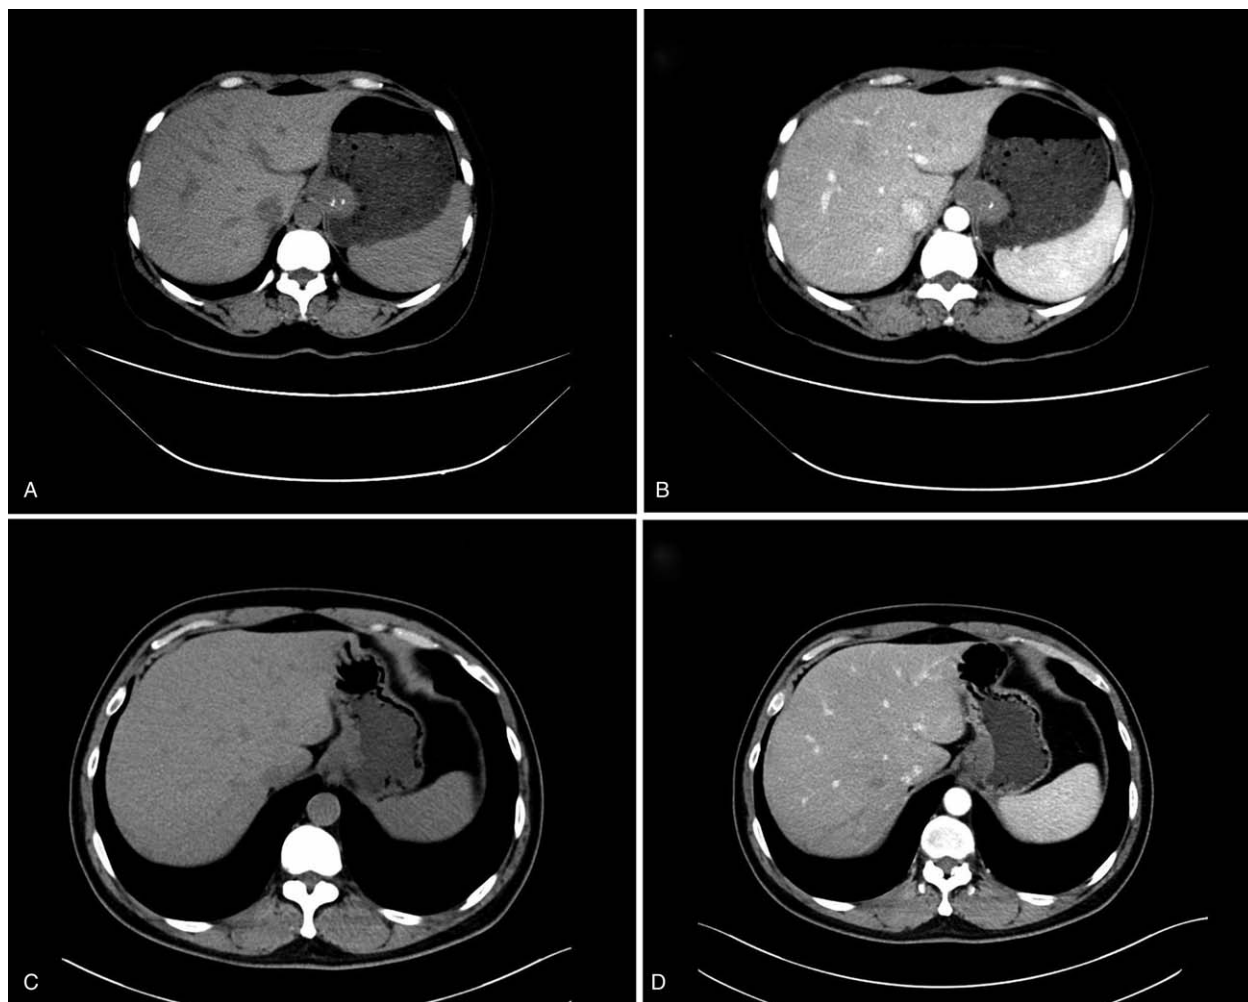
Leiomyoma in the esophagogastric junction. (A, B) 44-year-old woman with a 3.7-cm leiomyoma in the esophagogastric junction. CT images show homogeneous enhancement, low degree enhancement, lower CT attention value (58.1 HU, ≤ 69.2 HU), presence of calcification, absence of surface ulcer and intralesional low attention. A score of 0 was assigned. (C, D) 42-year-old man with a 3.6-cm leiomyoma in the esophagogastric junction. CT images show homogeneous enhancement, low degree enhancement, lower CT attention value (62.3 HU, ≤ 69.2 HU), absence of calcification, surface ulcer and intralesional low attention. A score of 1 was assigned.
